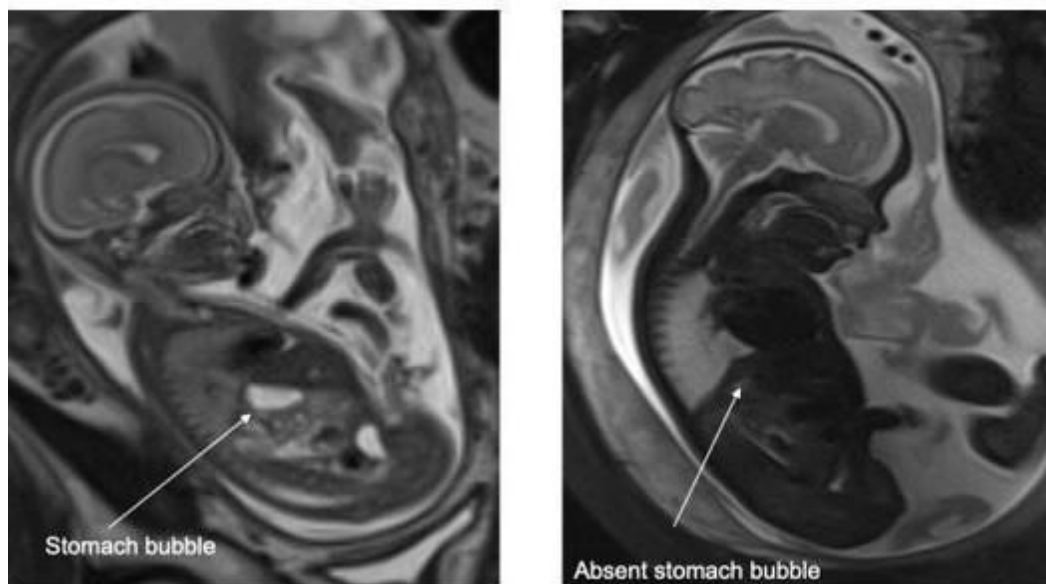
Sagittal T2 SSFSE fetal MRI images of normal stomach bubble size in 22 week fetus (left) in comparison with a small stomach bubble in a 30 week fetus with TOF/OA (right)
